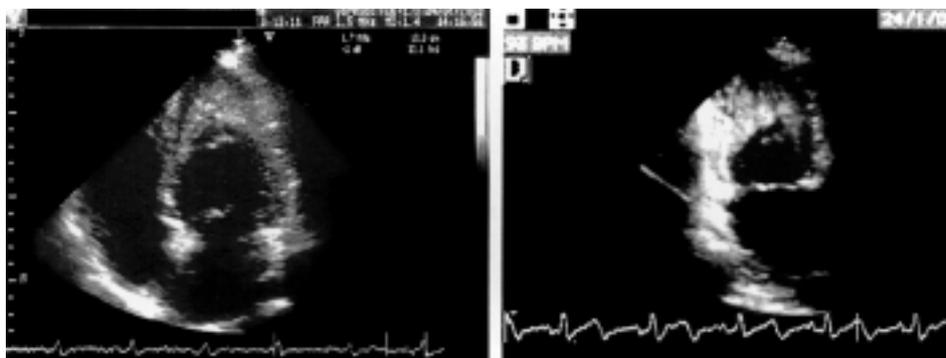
Tissue harmonic apical 4-chamber (left panel) and 2-chamber (right panel) views: an “in plus” image, suggestive of the presence of extensive endomyocardial eosinophilic infiltration, is evident in the left ventricular chamber at the level of the apical region.
